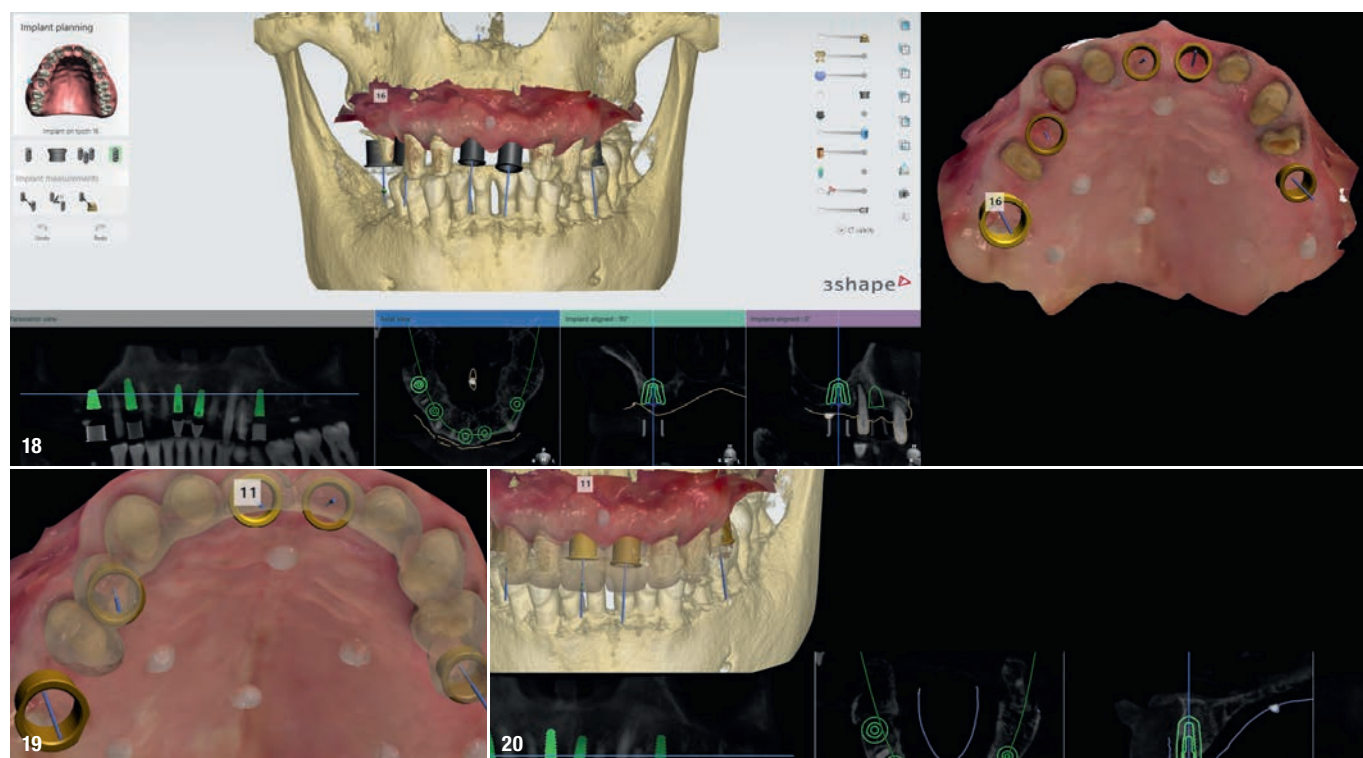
Intra-oral surface scans before and after removal of the original porcelain-fused-to-metal fixed partial prosthesis superimposed on to the CBCT scan. This facilitated the planning of implant placement from a restorative perspective.
